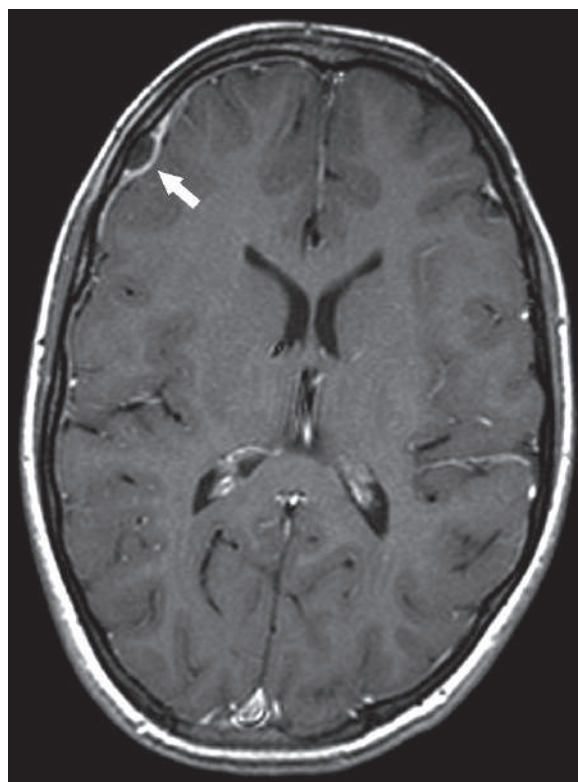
Axial T1W postcontrast brain MRI shows right frontal pachymeningeal enhancement with epidural abscess formation (arrow)
